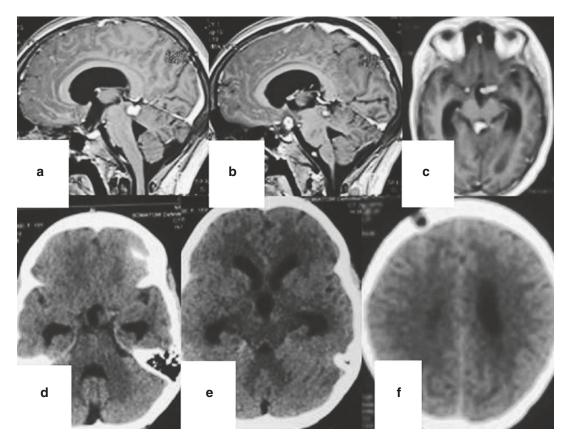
Contrast MRI of the brain; (a, b) sagittal images and (c) axial image showing TB lesion in the infundibulo-hypothalamic region, midbrain tectal area
